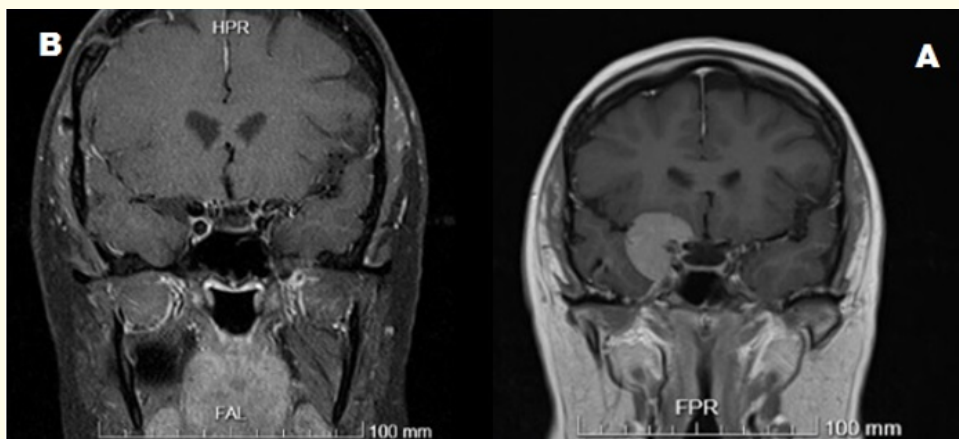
Coronal MRI cuts show a right side para-sellar meningioma (A) with post-operative image shows gross total resection(B) via a pterional approach.
